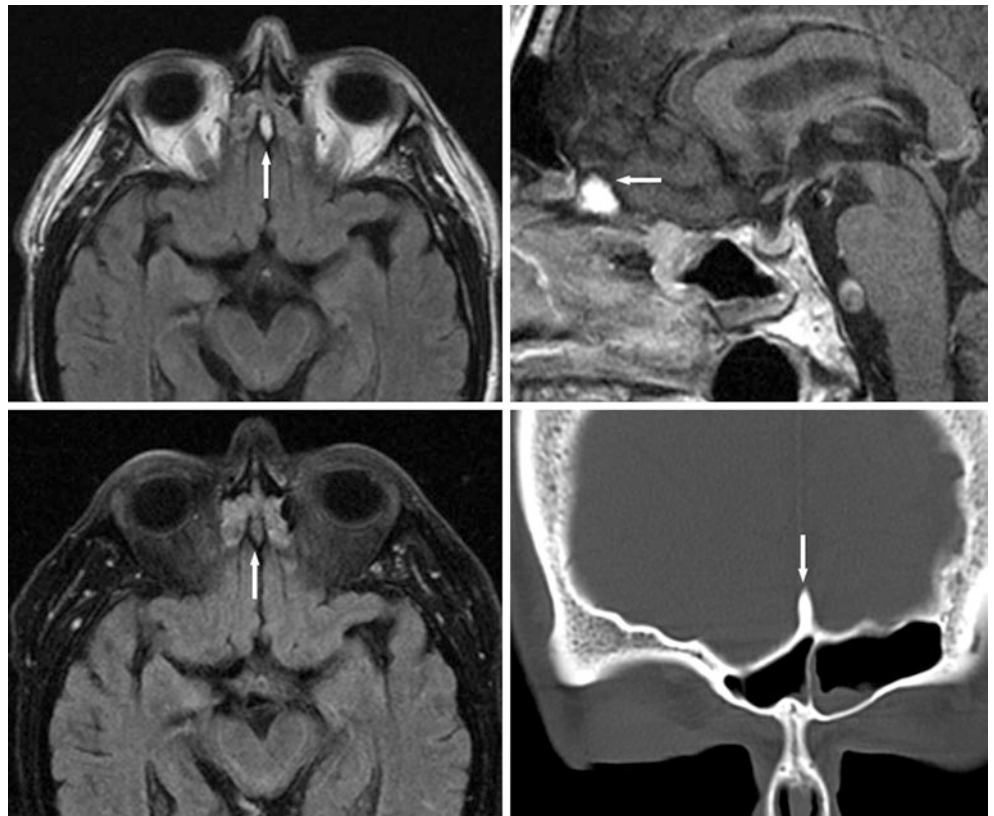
A 65 year old with a T1-bright crista galli on axial non-FS FLAIR (*top left*) and on sagittal postcontrast T1WI (*top right*) that became dark on axial FS FLAIR (*bottom left*) due to fatty marrow. This was dense on coronal CT (*bottom right*)
